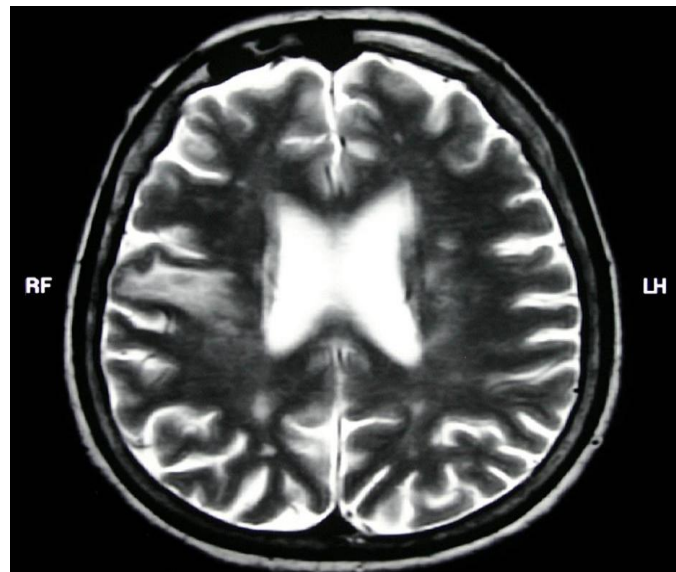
T2-weighted magnetic resonance image of the brain shows increased signal intensity on the right frontal operculum.
